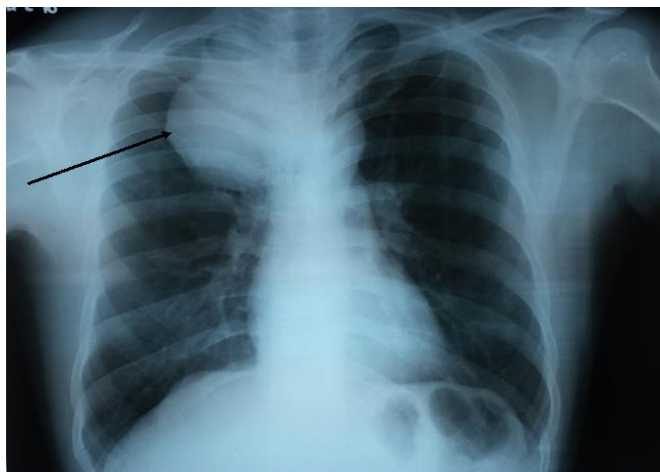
Chest radiograph (PA view)- A homogenous density mass measuring 10.2 x 9.3 cms is seen arising from superior aspect of middle mediastinum with well-defined lobulated margins occupying right upper and mid zones. The mass has a broad base toward mediastinum, seem to be arising from it. There is no calcification or cystic areas seen
